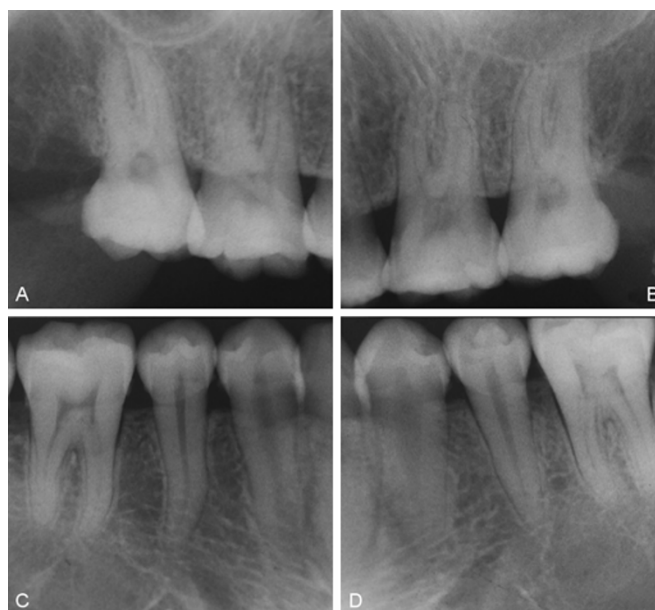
Radiographic views of corresponding teeth before treatment
